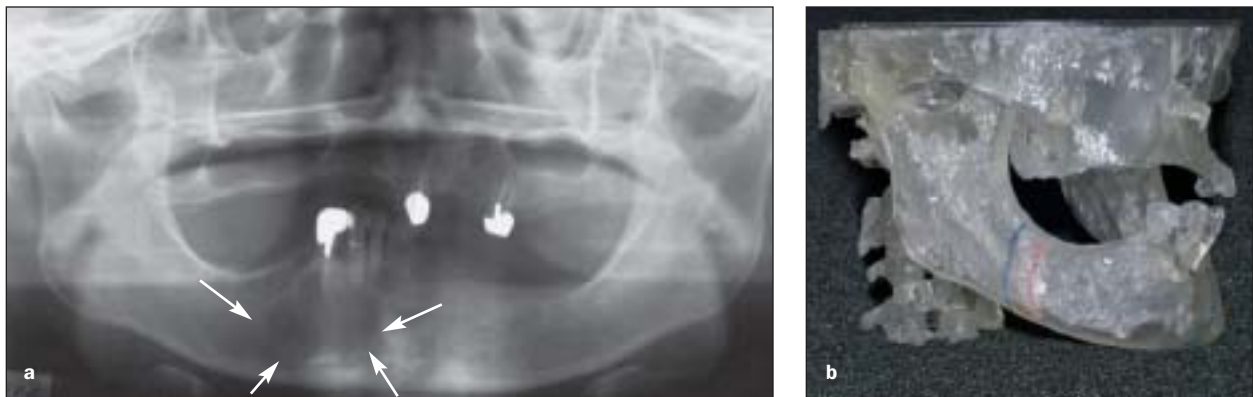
(a) A panoramic radiograph taken on the initial visit. (Arrows, tumor interface.) (b) A 3-dimensional model fabricated with stereolithography based on CT scans (blue line, area of planned excision).
